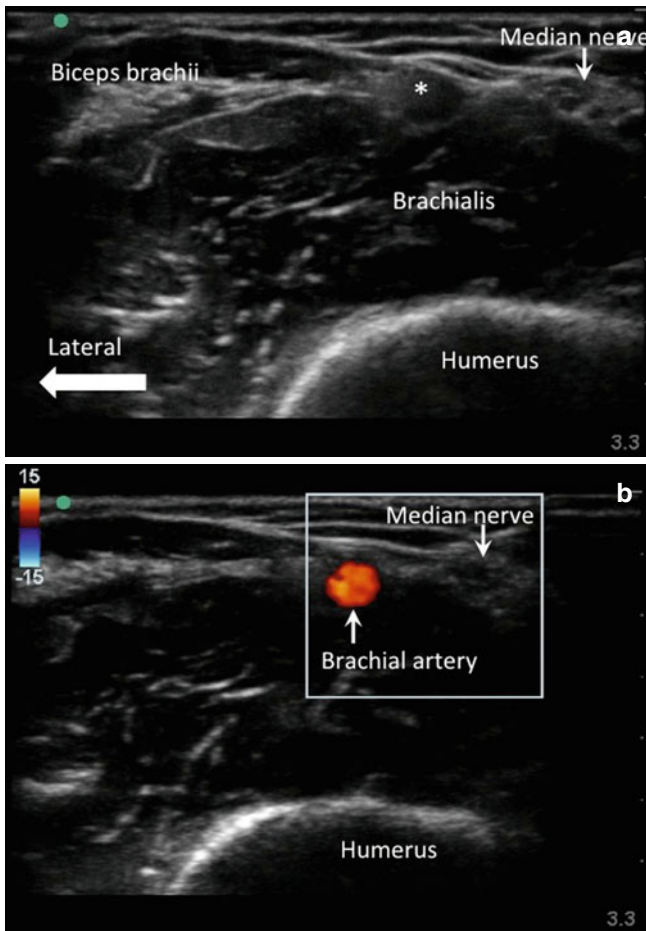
(a) Sonogram of the median nerve at the elbow level. The median nerve is seen medial to the biceps brachii tendons and lies on the surface of the brachialis muscle. * Indicates brachial artery. (b) Doppler scan of the brachial artery (Reproduced with permission from Philip Peng Educational Series)
